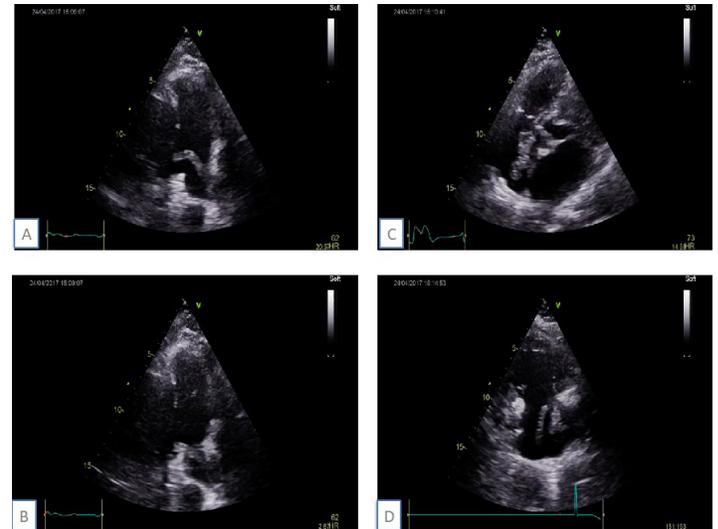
Transthoracic echocardiogram imaging showing movable thrombus of the pulmonary artery's bifurcation (A, B) and near the right auricle in apical 4 cavities (C) and 2 cavities (D).
